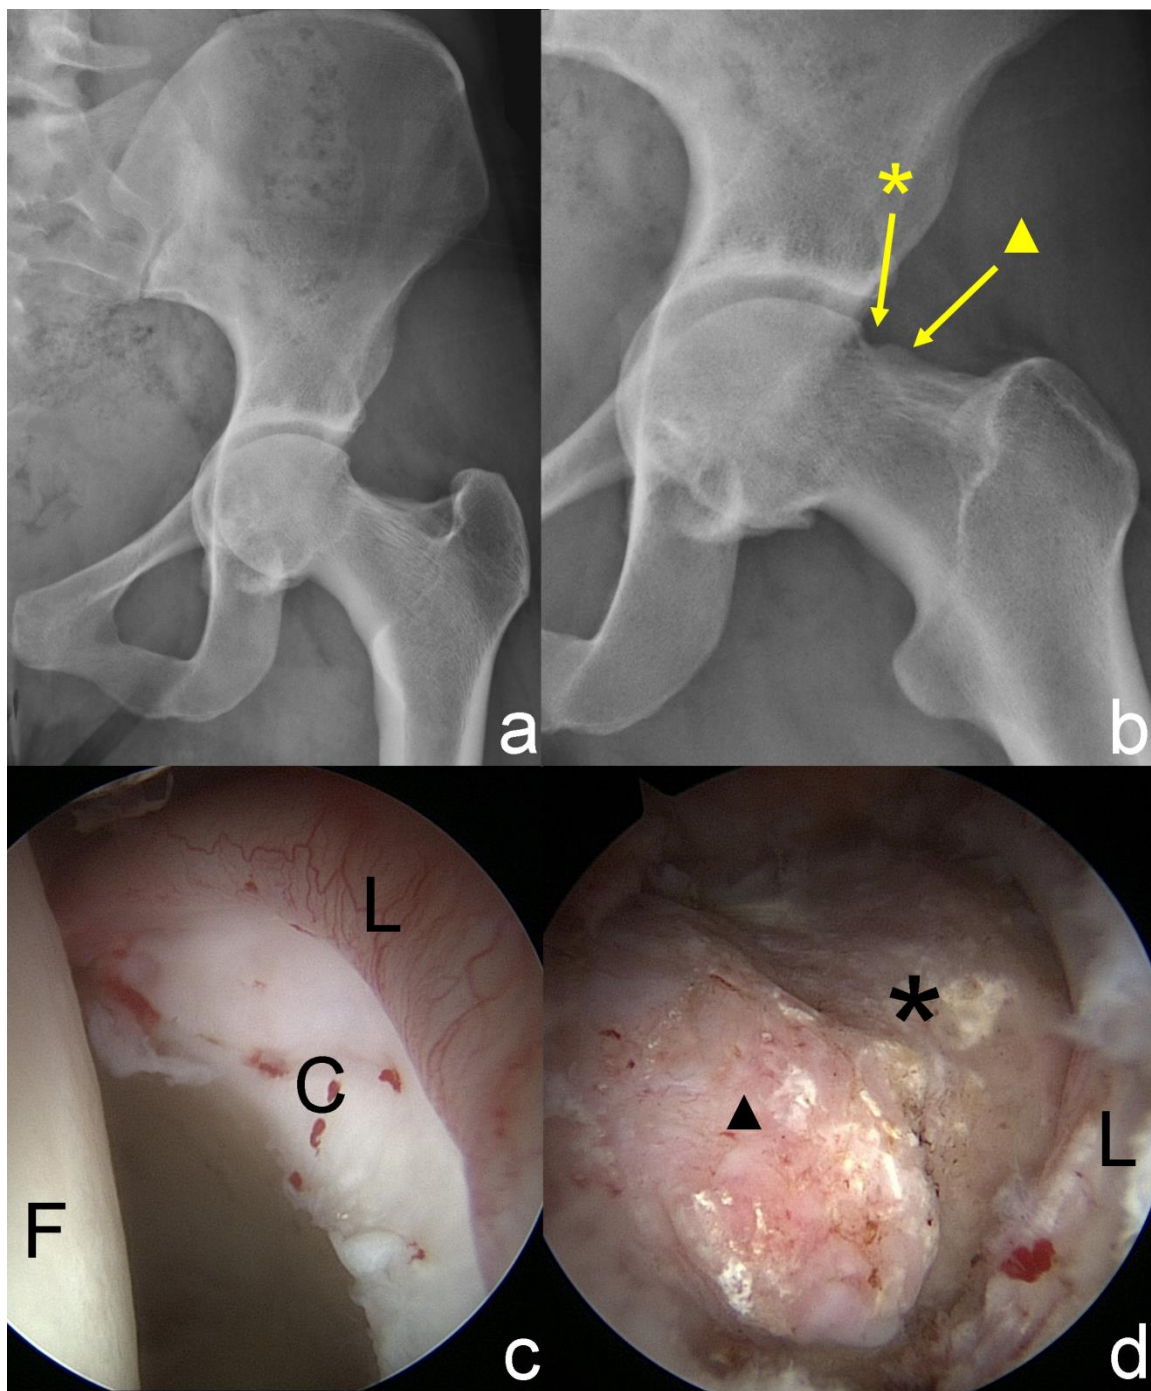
Radiographic and intraoperative imaging of the left hip of Patient 2. a) Anteroposterior radiograph showing protrusio. b) Frog-leg lateral radiograph showing pincer groove (*) and femoral neck prominence (▲). c) Arthroscopic view through the anterolateral portal (70 degree scope) of anterosuperior chondrolabral junction showing cartilage delamination. L=Labrum, F=Femoral Head, C=Cartilage Delamination d) Arthroscopic view of bony anatomy after soft tissue removal demonstrating large pincer groove and bony prominence on anterolateral femoral neck.
